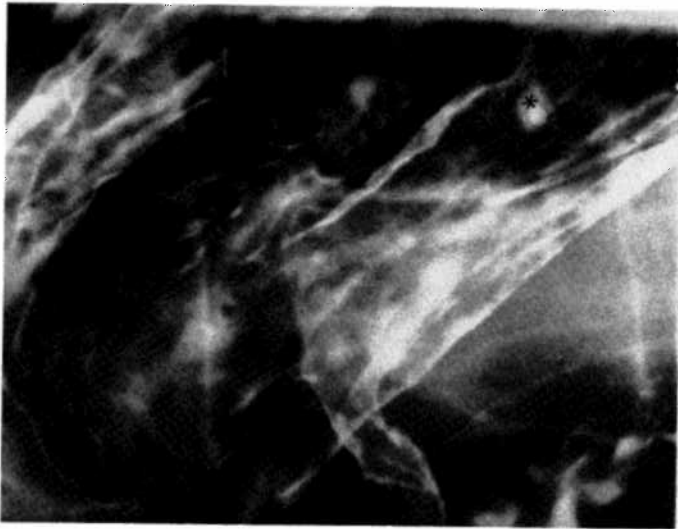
X-ray photograph of the nematode *Anisakis* in the wall of the stomach. The parasite appears beside the asterisk as a serpiginous 0.5 mm x 2 cm filling-defect. Note the small pool of barium, representing the site of attachment, partially surrounding the worm.
